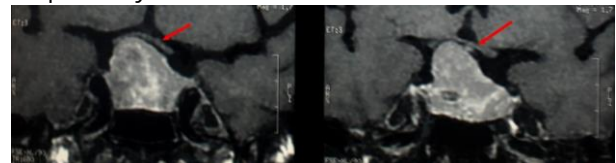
Case 1, Coronal MRI with contrast showing 3 X 3.5 X 3 cm lesion with severe chiasm displacement and stretch (Red arrow).
